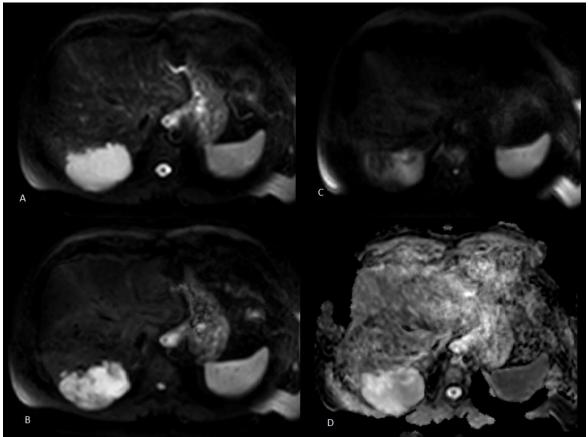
A case of hemangioma showing high signal on DWI at all b values (4A,4B,4C at 0,500,1000 b values) as well as on ADC (4D).
